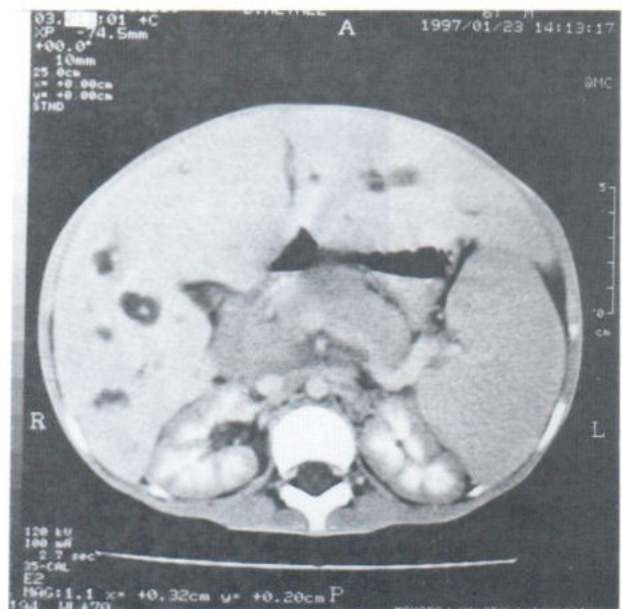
Contrast CT shows hepatosplenomegaly, saccular dilatation of the intrahepatic bile ducts, central dot sign, and striation of renal medullas of both kidneys.
